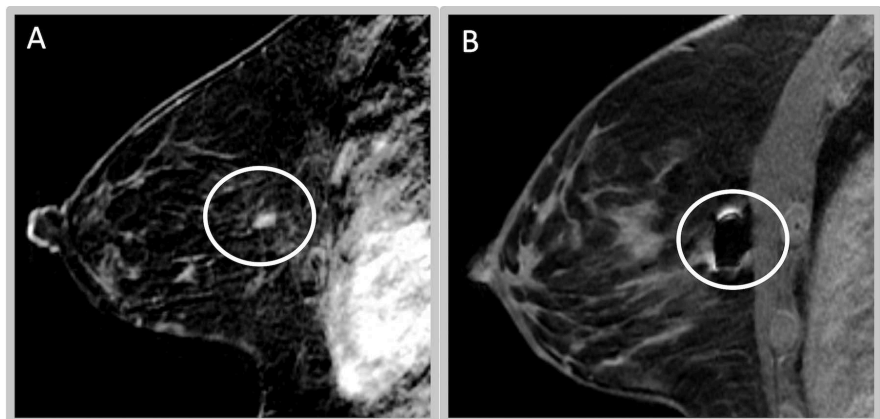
Case 3: A. Sagittal T1 FS subtraction CE MRI with an irregular mass in the left central breast posterior depth (circle) and biopsy image (B) showing the site appropriately sampled with air at the expected location (circle).
